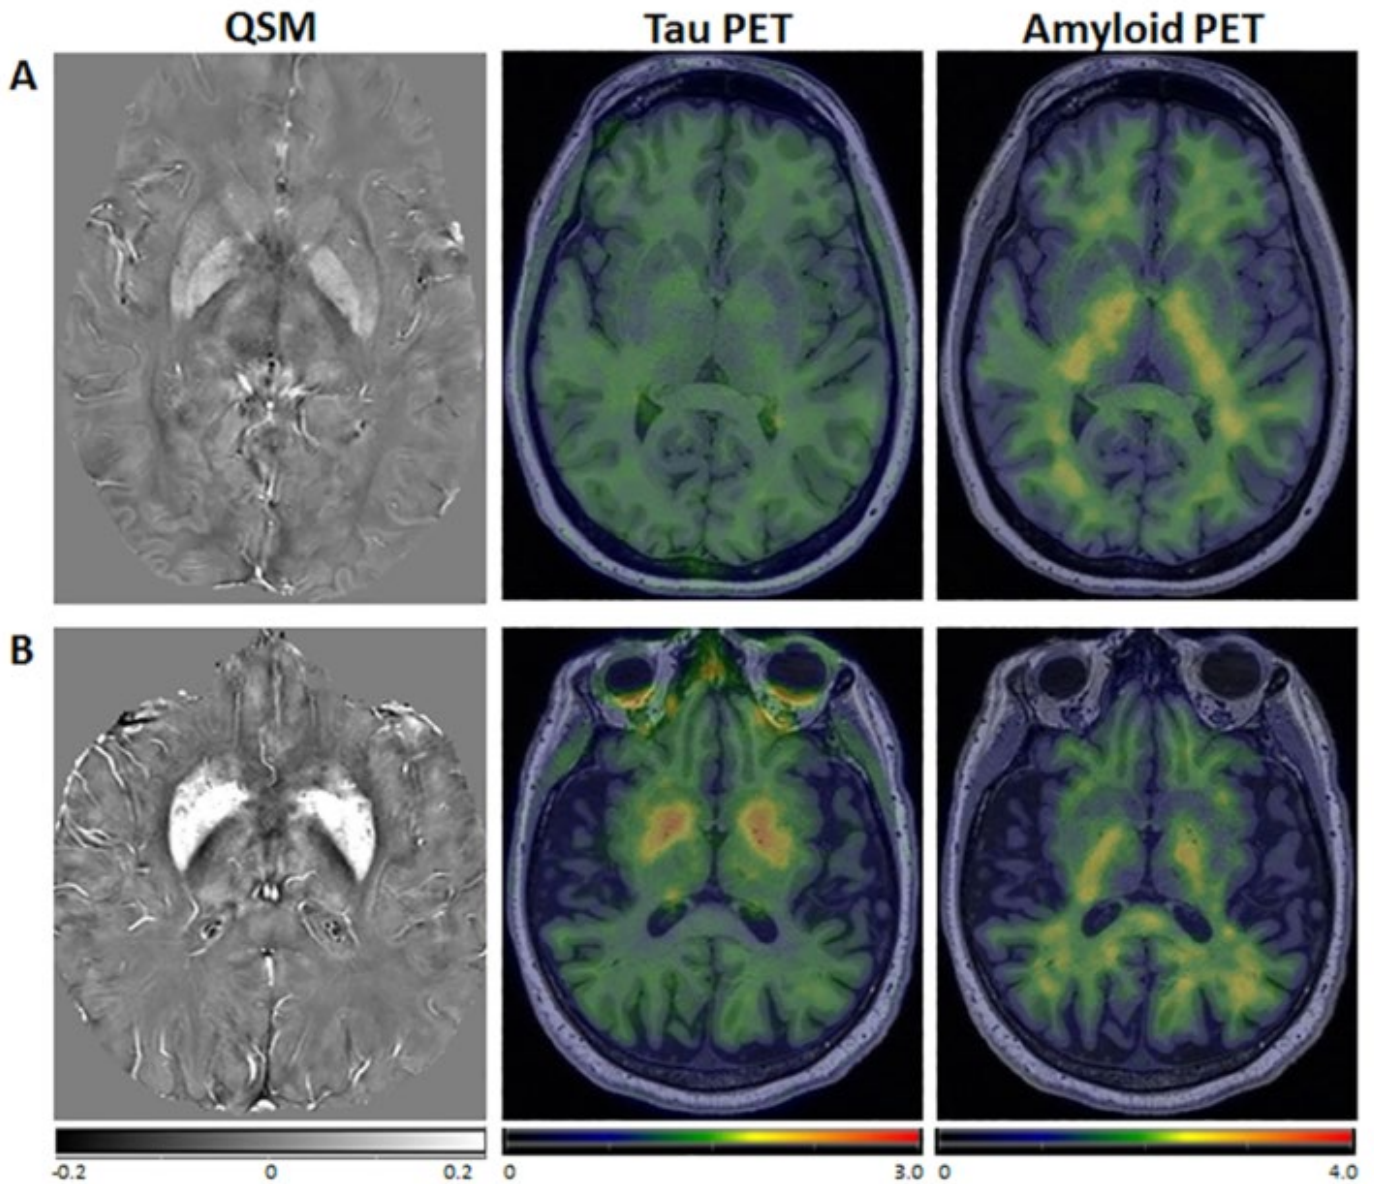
Images from representative participants. QSM, tau PET, and amyloid PET for (A) a 35-year-old participant and (B) an 80-year-old participant, both cognitively unimpaired. In the older participant, there was high signal in the pallidum and putamen on QSM with a similar distribution of elevated tau PET SUVR, which may be due to an increase with age in both off-target binding of the tau ligand and physiologic iron deposition in the basal ganglia. Amyloid PET SUVR was low throughout for both of the participants.
